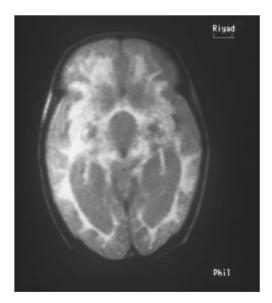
MRI of a patient with PTPS deficiency. There was increased T_1 signal intensity in the frontal lobe.
